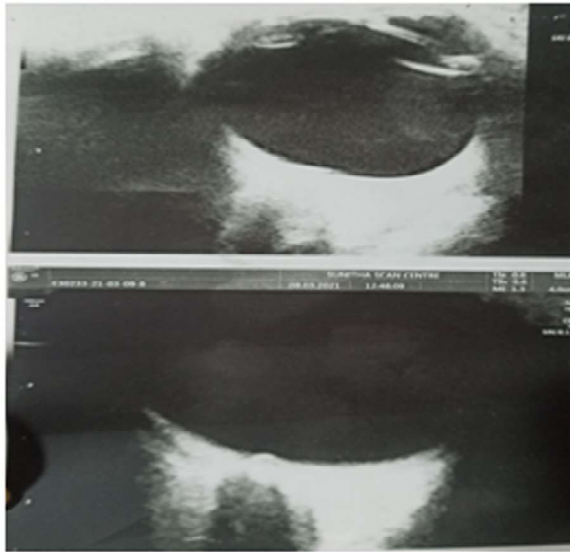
Ultrasound B-Scan.
